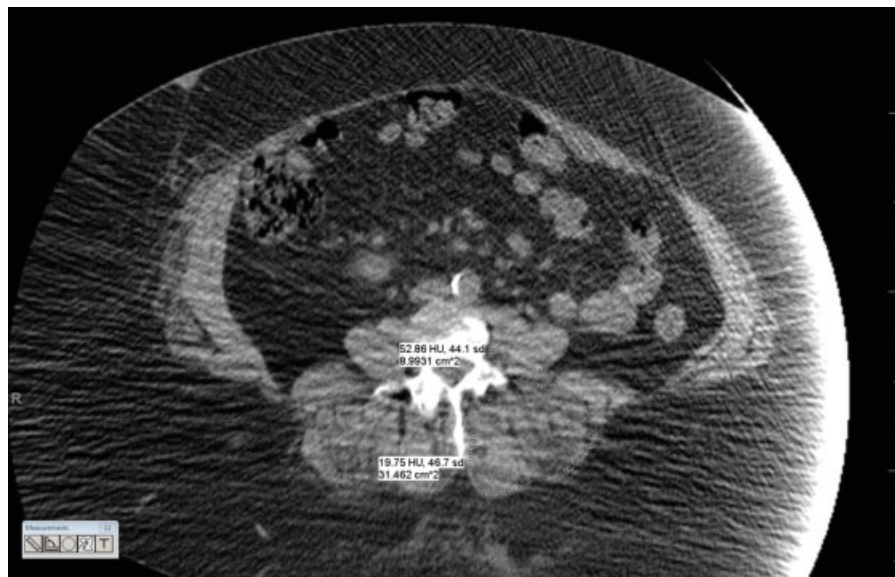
A 68-year-old woman presents for sarcopenia evaluation. Computed tomography at L4 shows a streak artifact that may invalidate the measurements of psoas and paraspinous muscles.
